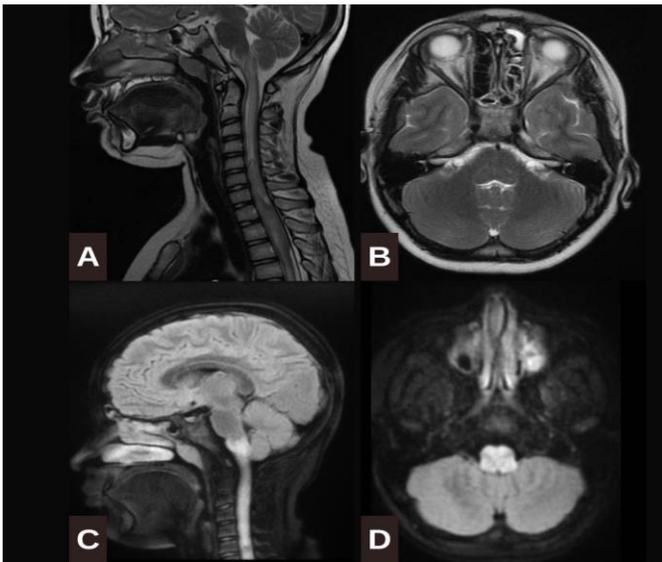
MRI findings of a pediatric patient with suspected neoplastic lesion in the spinal cord. (a) Axial and (b) sagittal sections demonstrate diffuse intramedullary signal alterations extending from the medulla oblongata to T4, with a tumefactive appearance and disruption of the hematospinal barrier at the C5 to T4 segment. (c) Axial and (d) sagittal sections depict normal signal intensity on T2-weighted sequences.
